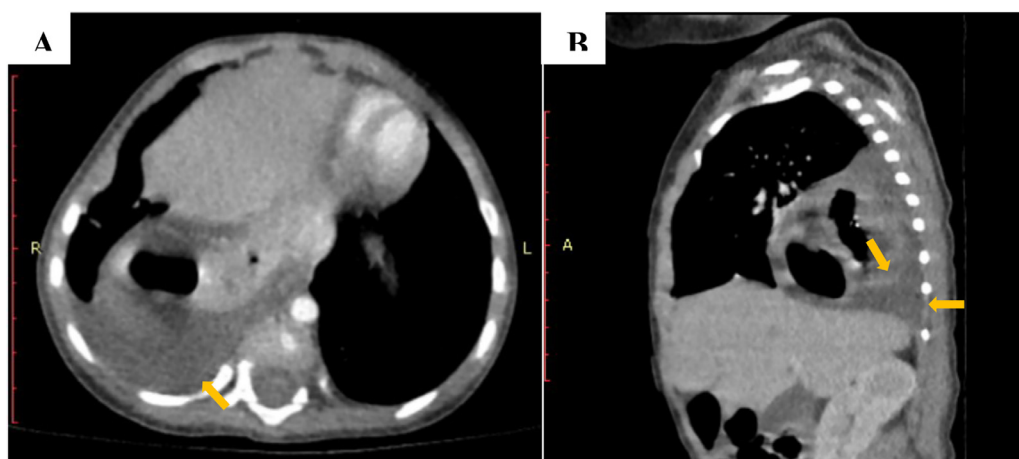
Axial (A) and sagittal (B) chest CT scans show right pleural effusion (yellow arrow).
